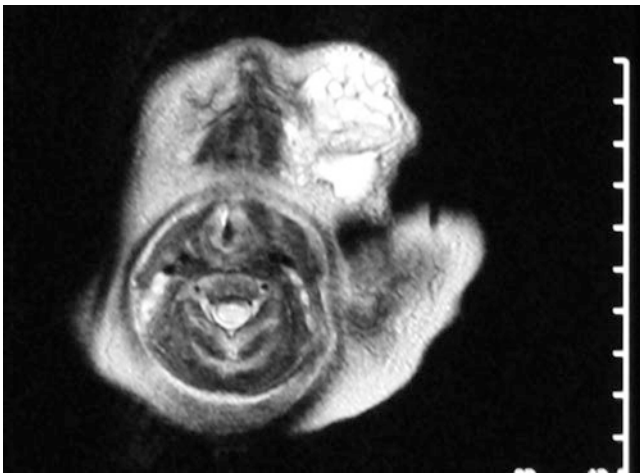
MRI (T2-weighted imaging) of a left cervical lymphatic malformation
